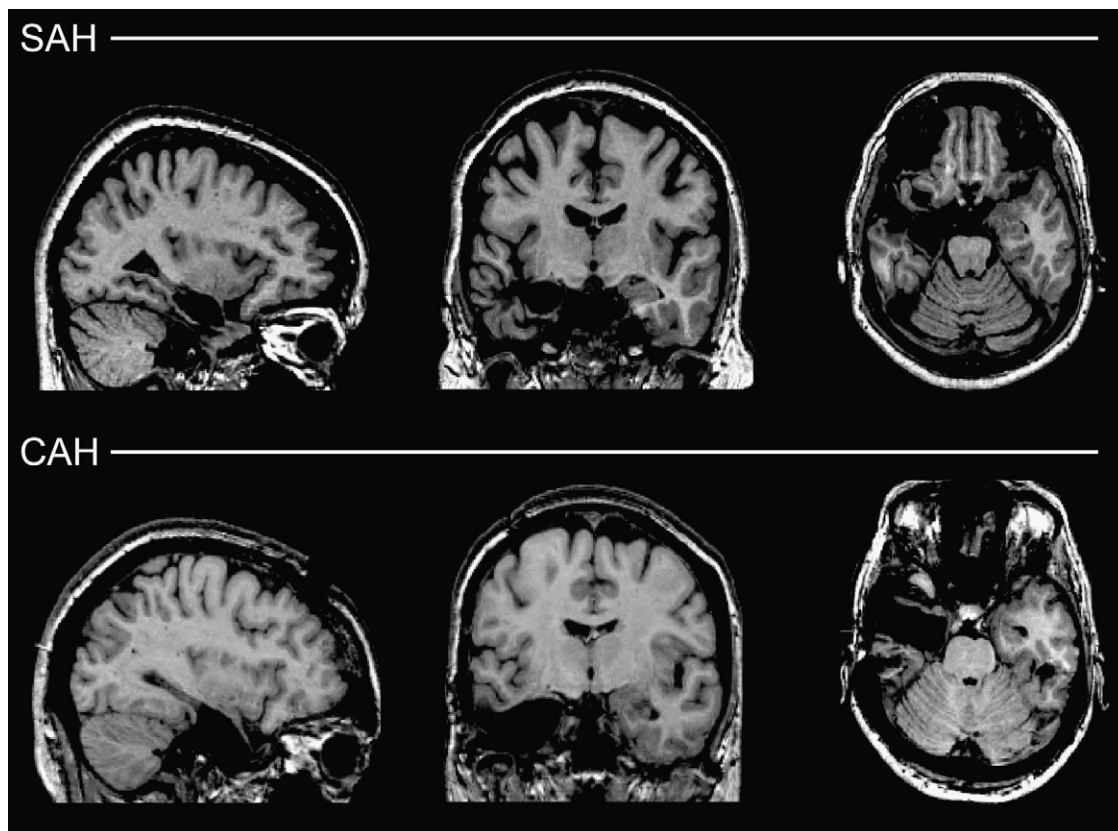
T1-weighted structural magnetic resonance images showing sagittal, coronal and axial slices of representative resections in patients with unilateral temporal lobe epilepsy. *Top row:* left hemisphere selective amygdalohippocampectomy (SAH). *Bottom row:* left hemisphere corticoamygdalohippocampectomy (CAH).
